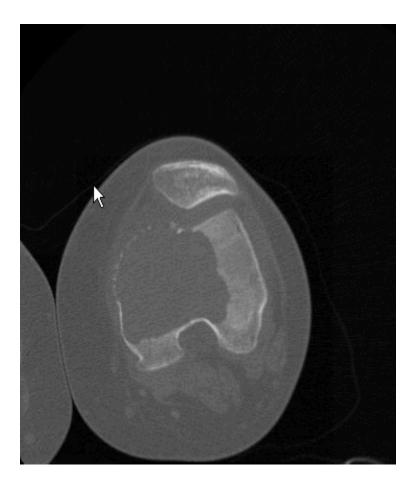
Computed tomography scan of giant cell tumor of bone of the distal femur. There
